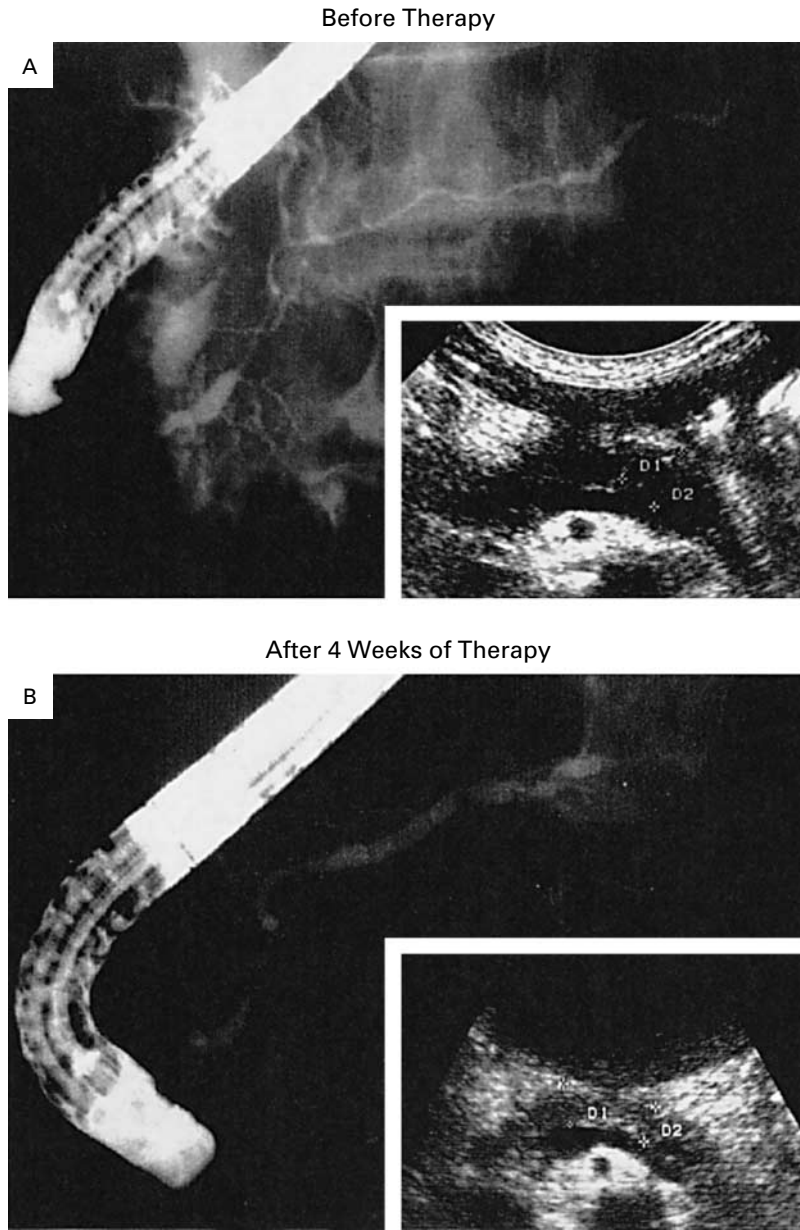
Findings on Endoscopic Retrograde Cholangiopancreatography and Ultrasonography (Insets) in a 72-Year-Old Woman with Sclerosing Pancreatitis.
